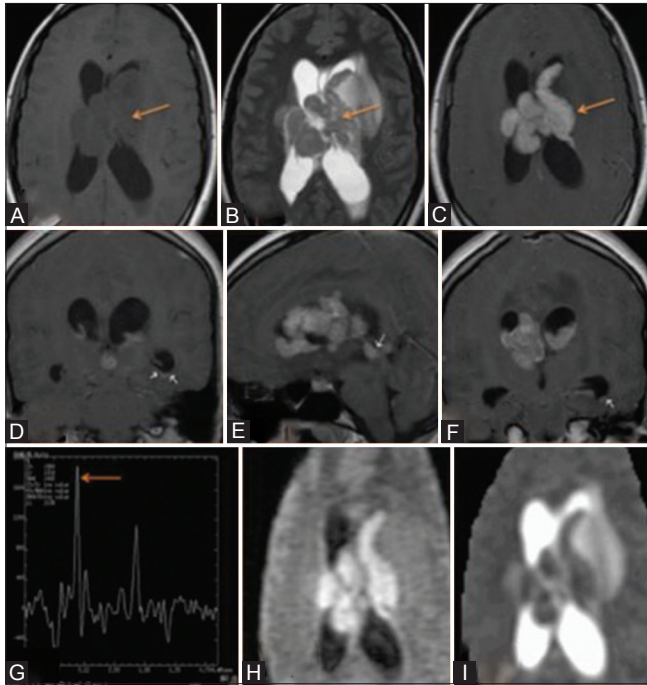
(A-I): History – A 22-year-old immunocompetent female presented with history of headache since a month, associated with nausea and vomiting. MRI showed an intraventricular lesion (arrows) located in the body of lateral ventricles isointense on T1W (A), hypo intense on T2W (B) images with homogenous enhancement on post-contrast study (C). More post-contrast T1 images (D-F) showed sub endypmal enhancement (arrows in D); additional enhancing lesions in the posterior third ventricular location (arrow in E); enhancing sub endypmal nodule in the left temporal horn (arrow in F). There was a choline peak (arrow) on MRS (G). There was restricted diffusion noted within the intraventricular lesion on diffusion weighted and apparent diffusion coefficient images (H and I)
